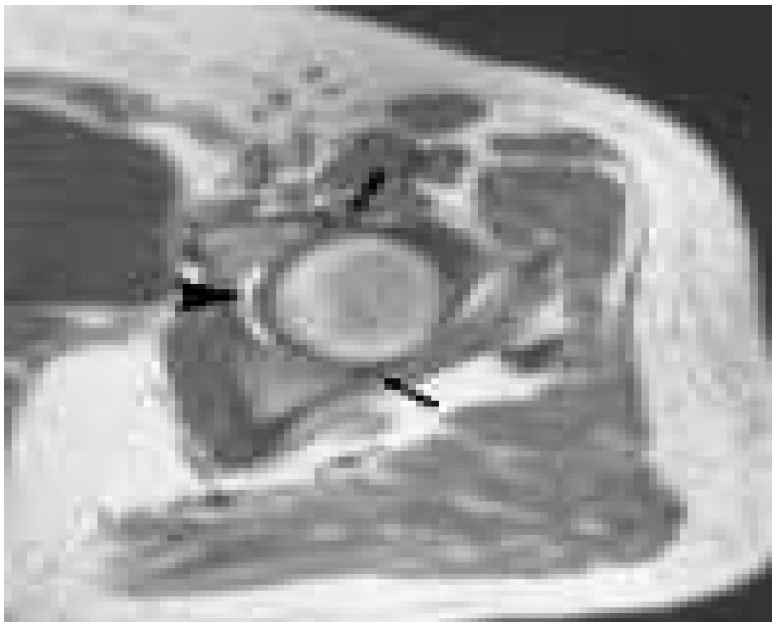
Normal adult hip.Axial T1-weighted. Its anterior and posterior rims are clearly defined (arrows). Centrally located within acetabulum is fat surrounding the ligamentum teres (arrowhead) (David et al., 2004).
